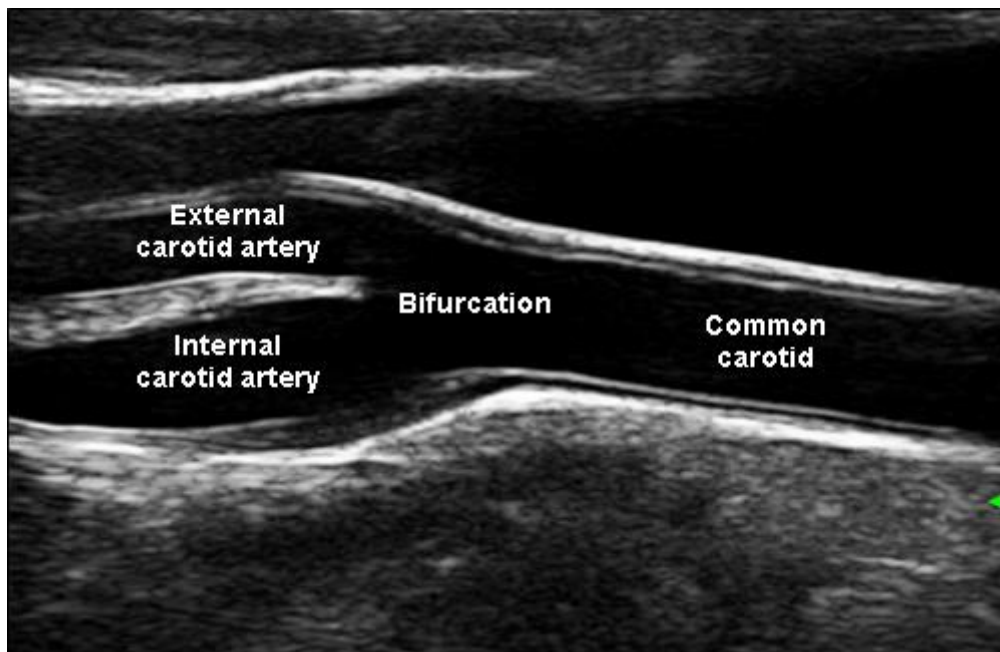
Ultrasonographic anatomy of common carotid, bifurcation, internal and external carotid arteries.
